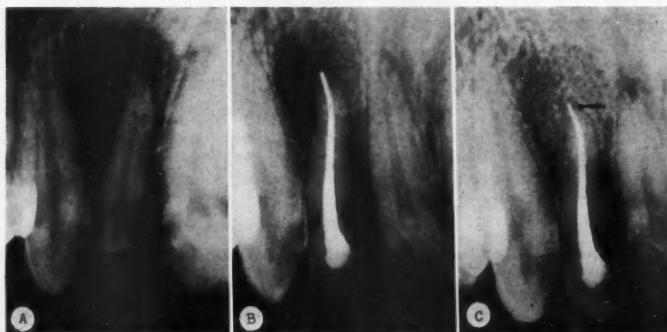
A, Roentgenogram made at appointment when endodontic therapy was undertaken. B, Roentgenogram made at completion of obturation; note position of arrow, and that root canal is slightly underfilled. C, Roentgenogram made one year following completion of therapy. Note resolution of area of peripapical radiolucency, and position of arrow. As a result of a slight amount of root resorption, the obturator is now long or overextended.
